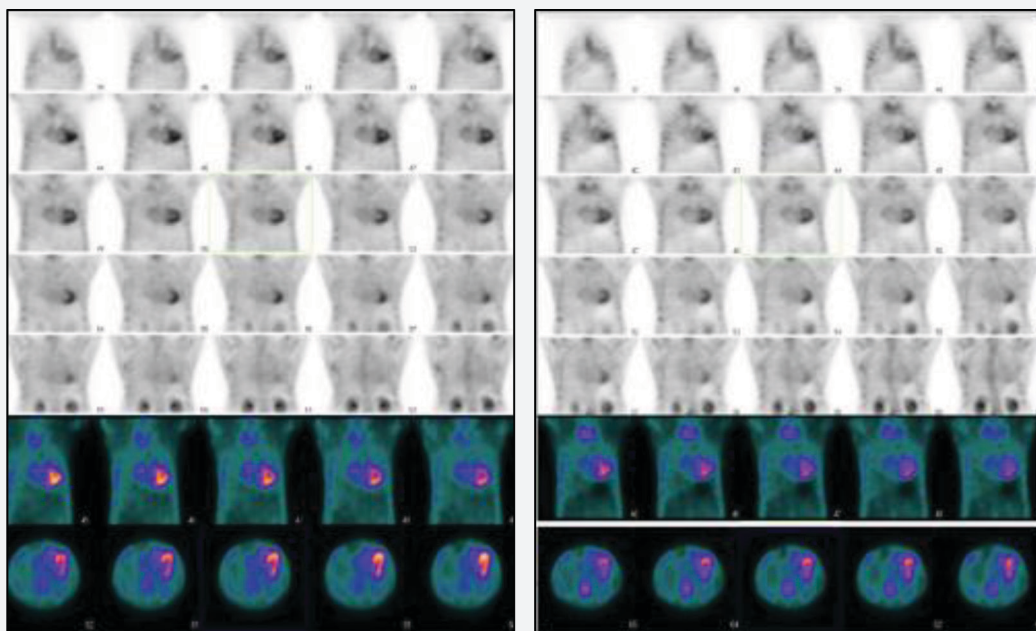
Overview tomographic acquisition done with the planar and SPECT views, taken 1 hour (left image) and 3 hours (right image) after injecting 15.92 mCi of TC-99m PYP showing a greater myocardial uptake with mild to absent rib uptake and PERUGINI score of 3.
